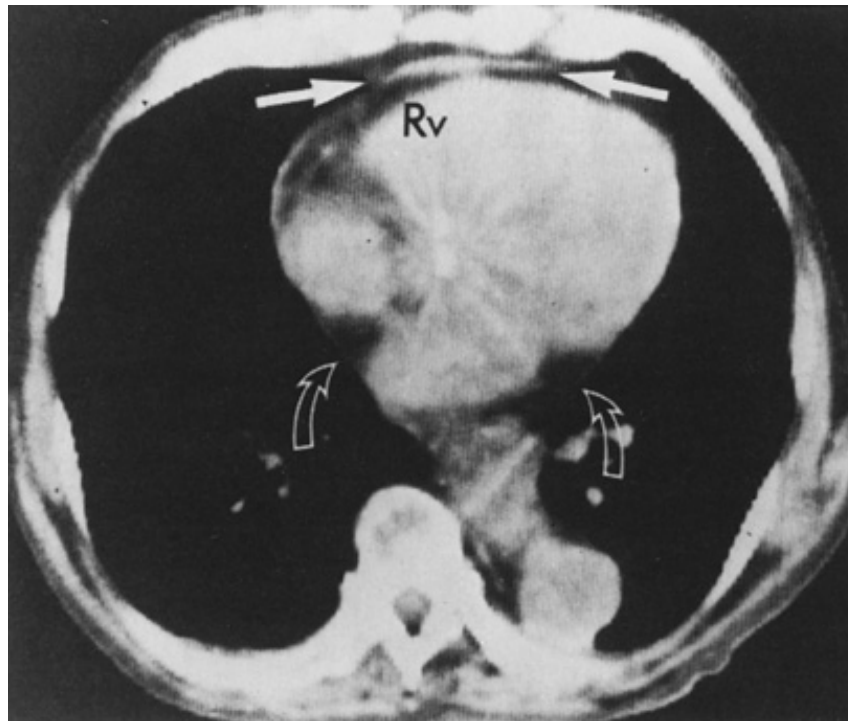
Computed tomographic (CT) scan shows the normal pericardium as a thin, curvilinear line (*open arrows*). The increased thickening over the anterior surface of the heart
